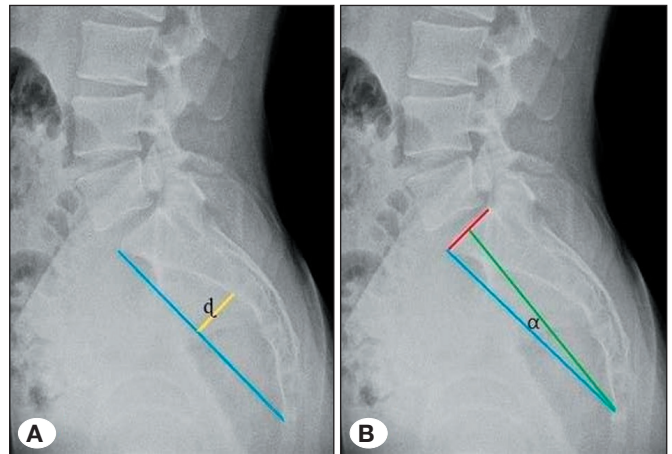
Lateral lumbosacral radiograph demonstrating the measurement methods of "ATA1" distance (d) in "mm" (A) and "ATA2" angle (α) in "degree °" (B).
